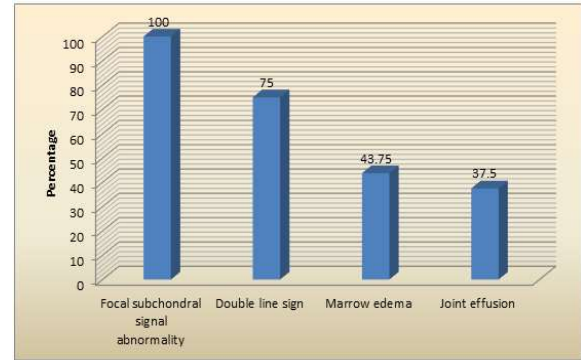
MRI findings in AVN
